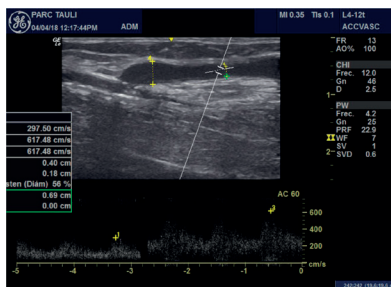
Doppler Mode. Stenosis 56%. Ratio stenosis / pre-stenosis (617 / 297 cm/s) = 2.
